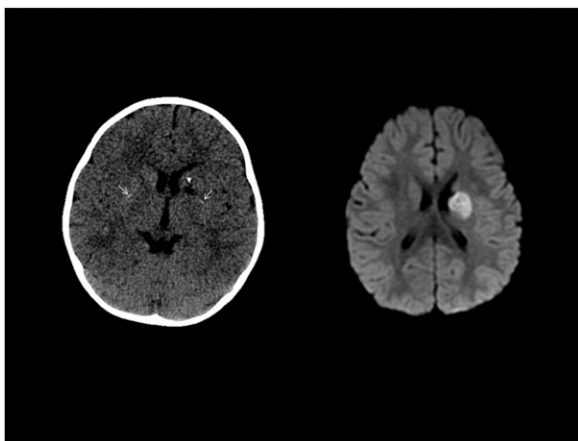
Left, Axial noncontrast computed tomographic scan demonstrating small linear calcifications in both putamina (arrows) and small chronic infarct involving the left caudate head and internal capsule (arrowhead). Right, Diffusion-weighted magnetic resonance image from the same day demonstrating a larger acute left basal ganglia infarct.
